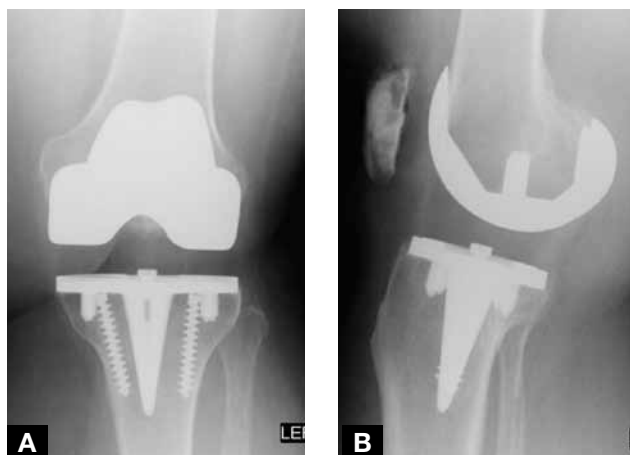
(A, B) At 15 years, radiographs of NK-I system with cementless fixation of femoral component and stemmed tibial baseplate.
